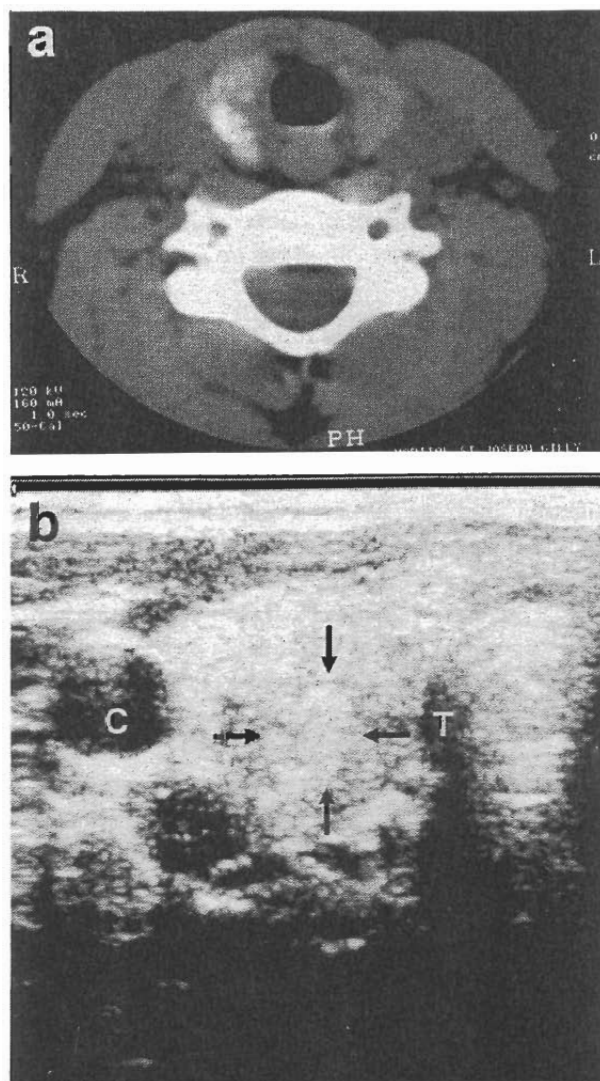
Computed tomography (CT) (a) and ultrasound (US) (b) scans of the thyroid of patient 2, showing psammoma bodies. In the CT, punctate calcifications can be clearly seen on the right. In the US, microcalcifications (arrows) are observed inside the right lobe. C = carotid artery; T = trachea.
